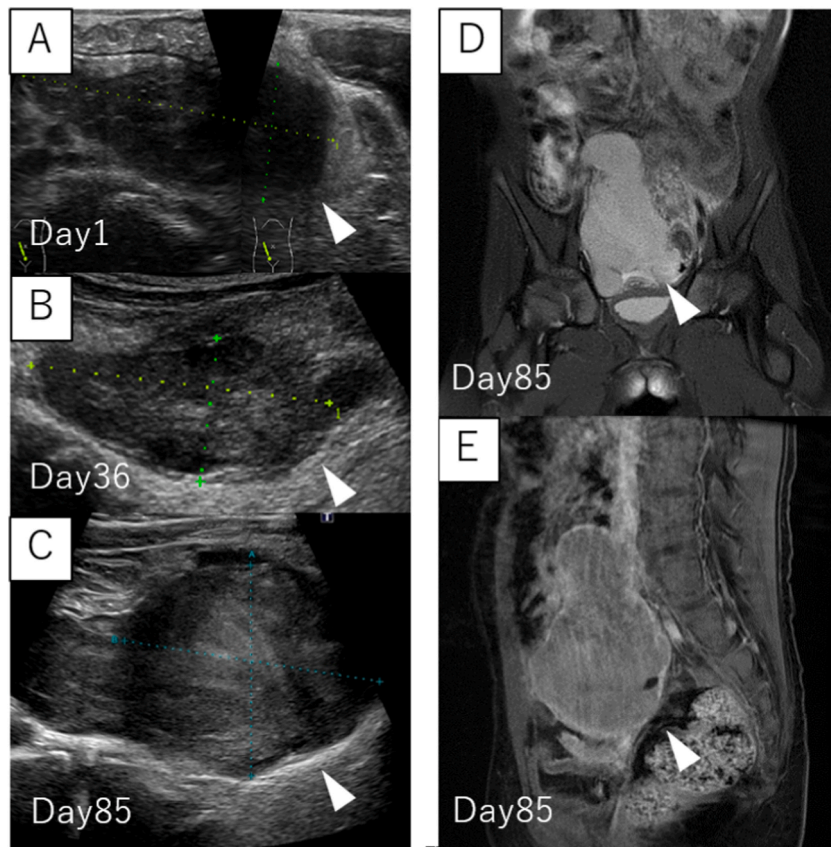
(A,B,C) Ultrasonography demonstrated an appendiceal mass suggesting peri-appendiceal abscess (white arrow) with overall diameter 27 mm at day1, 33mm at day 36 and 48mm at day 85, respectively.
